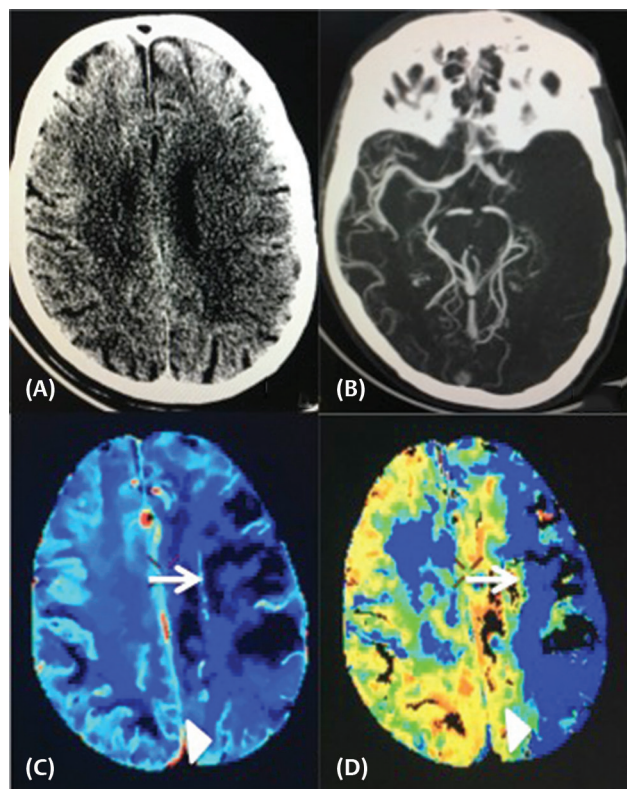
Noncontrast computed tomography (CT) (A), axial maximum intensity projection (MIP) (B) CT angiography and subsequent CT perfusion-based cerebral blood volume (CBV, C) and mean transit time (MTT, D) maps demonstrating left middle cerebral artery (MCA) thrombus with a large infarct core (reduced CBV and prolonged MTT, arrow) and a small ischemic penumbra (maintained CBV but prolonged MTT) posterior to it (arrowhead).
